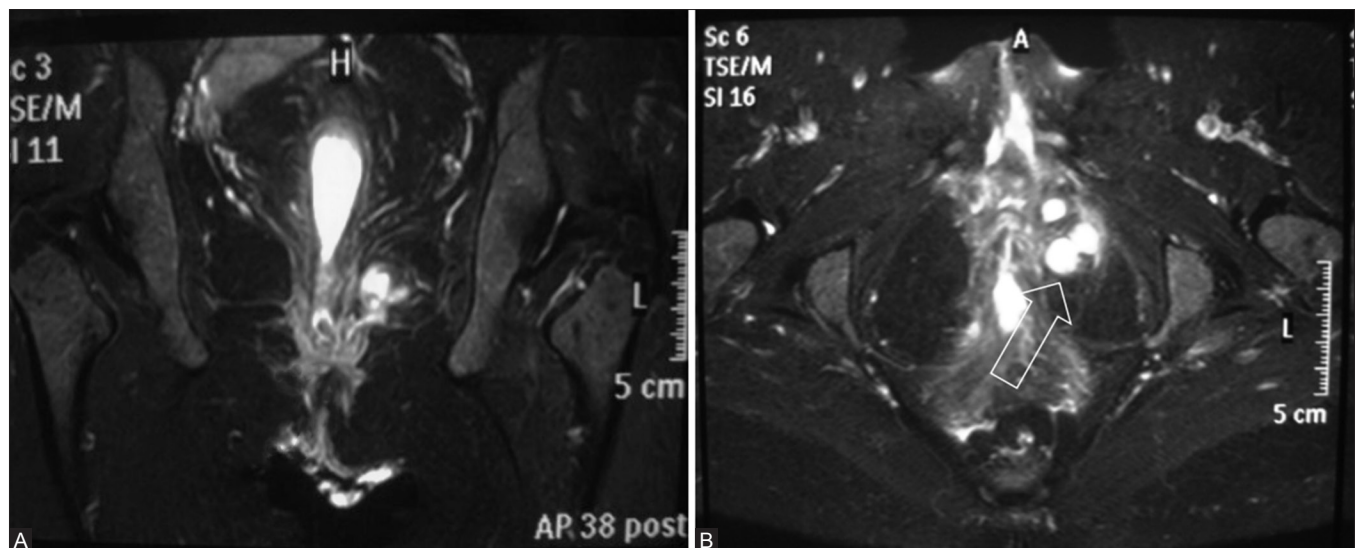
Perianal fistula in CD. T2-weighted coronal (A) and axial (B) images showing complex fistulous tract and collections (arrow) in the left ischioanal fossa. Fistula and sinus tracts are markers of inflammatory stage in CD
